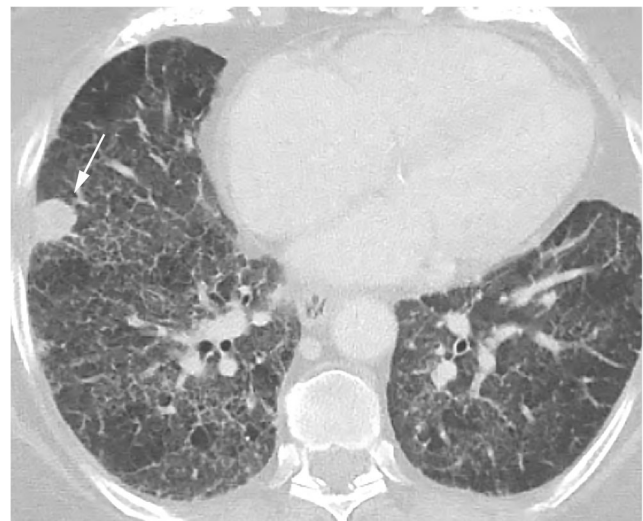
HRCT of a scleroderma patient with pulmonary fibrosis (extensive reticular abnormality) shows a right middle lobe nodule lung nodule (*arrow*), which was biopsy-proven to represent lung cancer. HRCT high-resolution computed tomography
